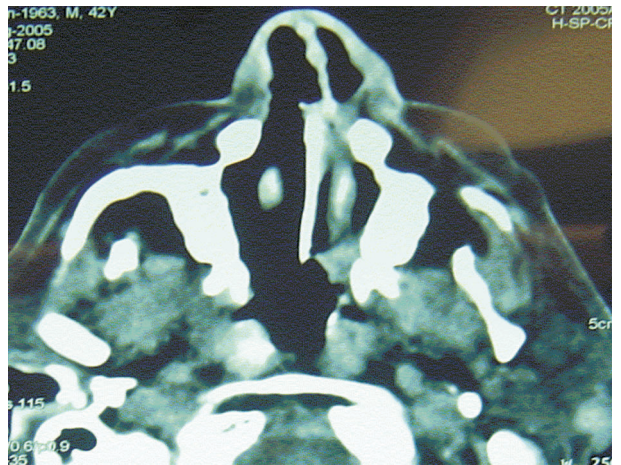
Computed tomography axial scan of ethmoid sinuses showing a partial opacification of the left ethmoid sinus.
